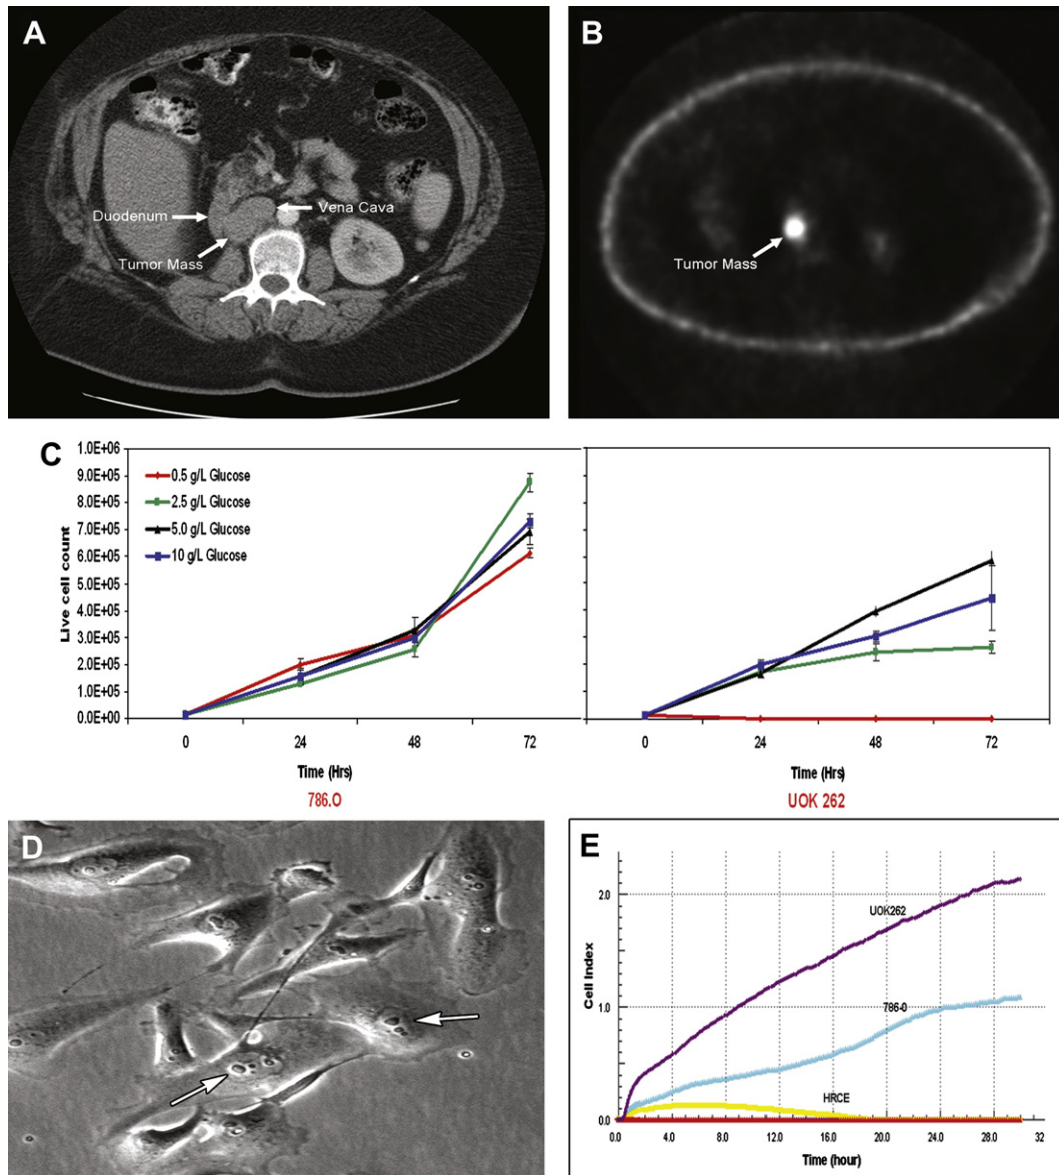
(A) Abdominal computed tomography scan reveals a recurrent, right retroperitoneal tumor mass in a patient with hereditary leiomyomatosis renal cell carcinoma (HLRCC). (B) [ $^{18}\text{F}$ ]fluorodeoxyglucose positron emission tomography imaging of the patient reveals strong glucose uptake in the lymph node tumor metastasis. (C) The in vitro growth of UOK 262 cells in 0.5, 2.5, 5, and 10 g/L D-glucose. Proliferation and survival of the cells were glucose dependent. (D) The morphology of UOK 262 cells in culture, showing active branching and the unique HLRCC pathological features of large nuclei with predominant nucleoli and atypical perinucleolar clearing (arrows) (40 $\times$ ). (E) Real-time assay of the invasive potential of UOK 262 cells, compared with control cells (786–O) and normal renal cortical epithelial cells (HRCE).
